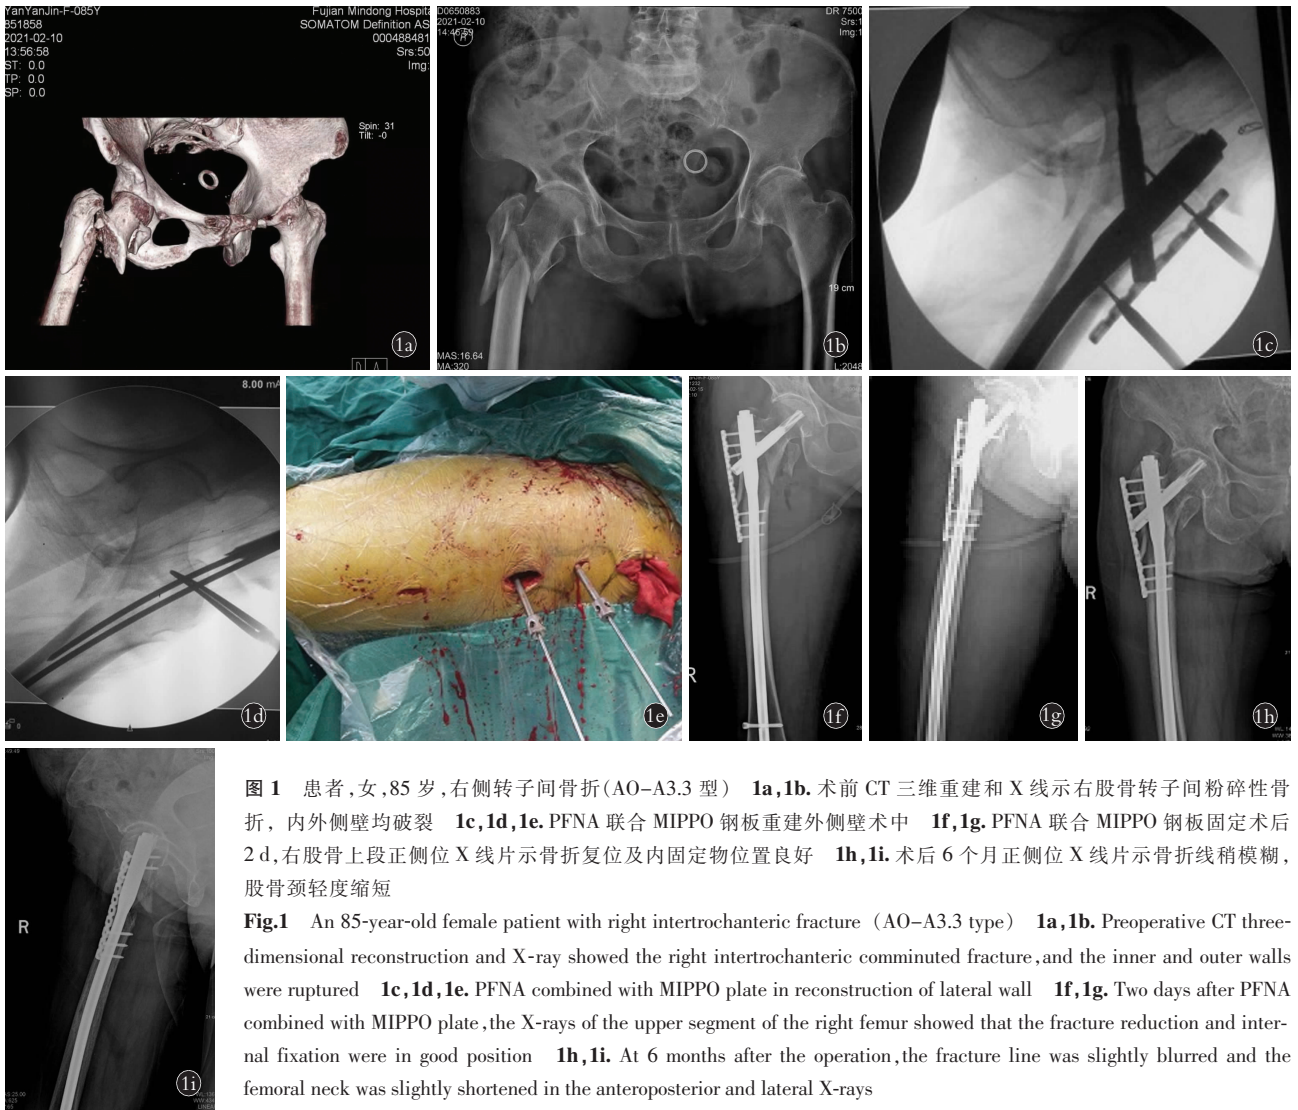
患者,女,85 岁,右侧转子间骨折(AO-A3.3 型) 1a,1b. 术前 CT 三维重建和 X 线示右股骨转子间粉碎性骨折,内外侧壁均破裂 1c,1d,1e. PFNA 联合 MIPPO 钢板重建外侧壁术中 1f,1g. PFNA 联合 MIPPO 钢板固定术后 2 d,右股骨上段正侧位 X 线片示骨折复位及内固定物位置良好 1h,1i. 术后 6 个月正侧位 X 线片示骨折线稍模糊,股骨颈轻度缩短
